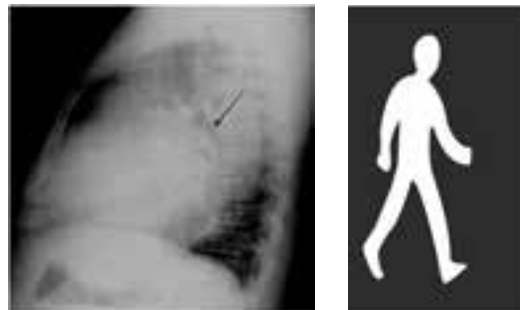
Walking man sign. Lateral chest X-ray demonstrates posterior displacement of the left mainstem bronchus, mimics inverted V or a Walking man.
